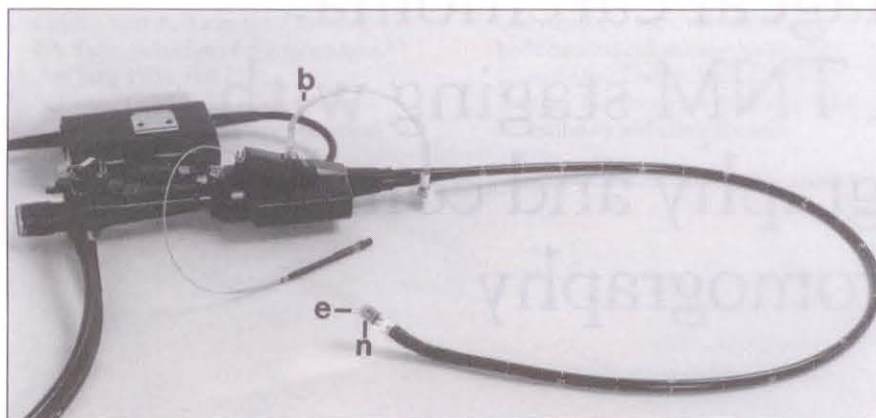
An Olympus echoendoscope (EU-M3) loaded with a small echoprobe (e) and a switch for changing the ultrasound frequency from 7.5 to 12 MHz. A sclerosing needle (n) passes through the instrumental channel for aspiration cytology. b Channel for filling the balloon with water
